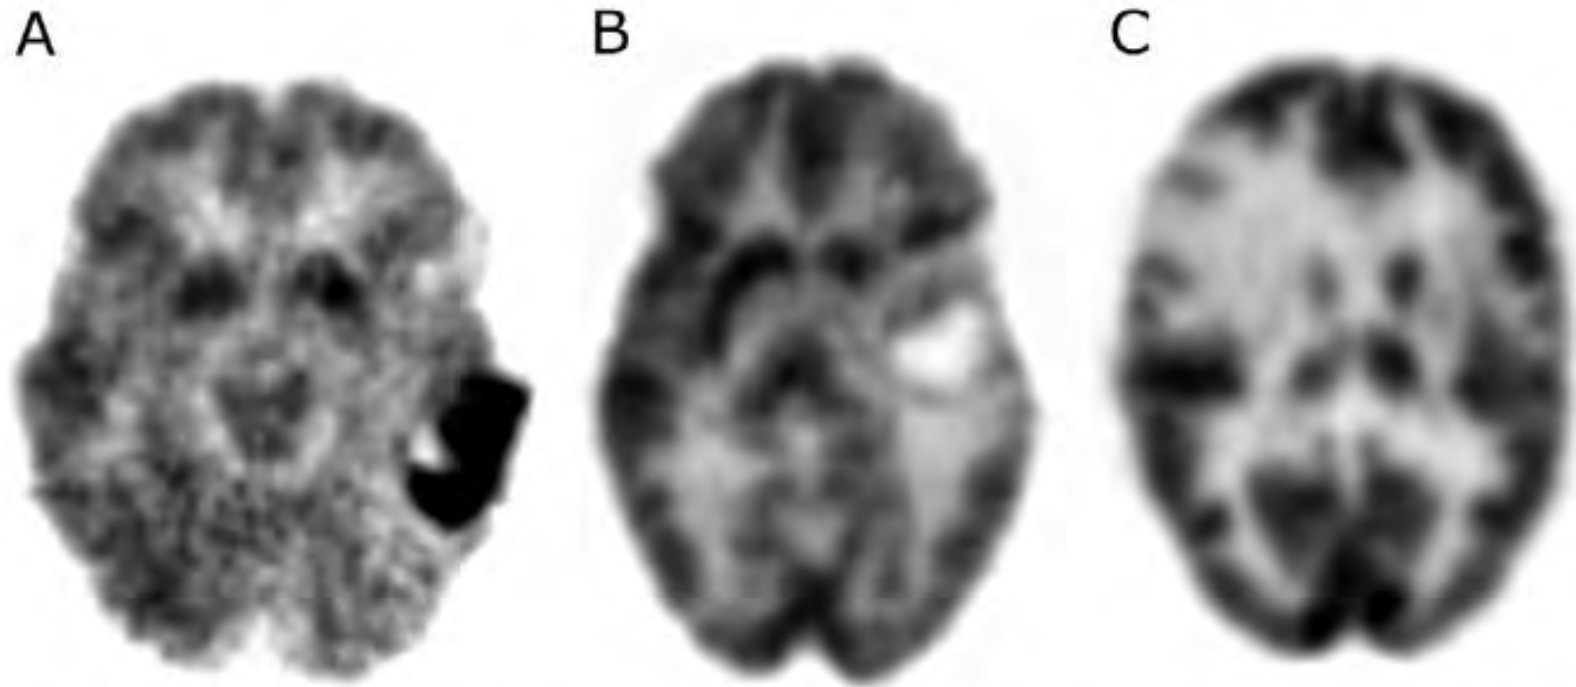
Variable FDG-PET uptake in newly diagnosed tumors. (A and B) Left temporal glioblastoma; (C) right frontal grade II mixed glioma.
